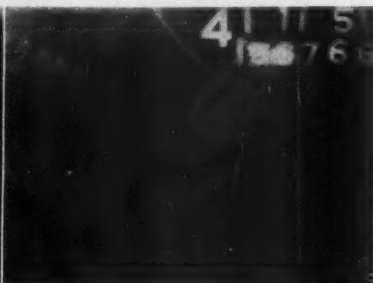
Oblique roentgenogram view showing Lipiodol in small intestine.
